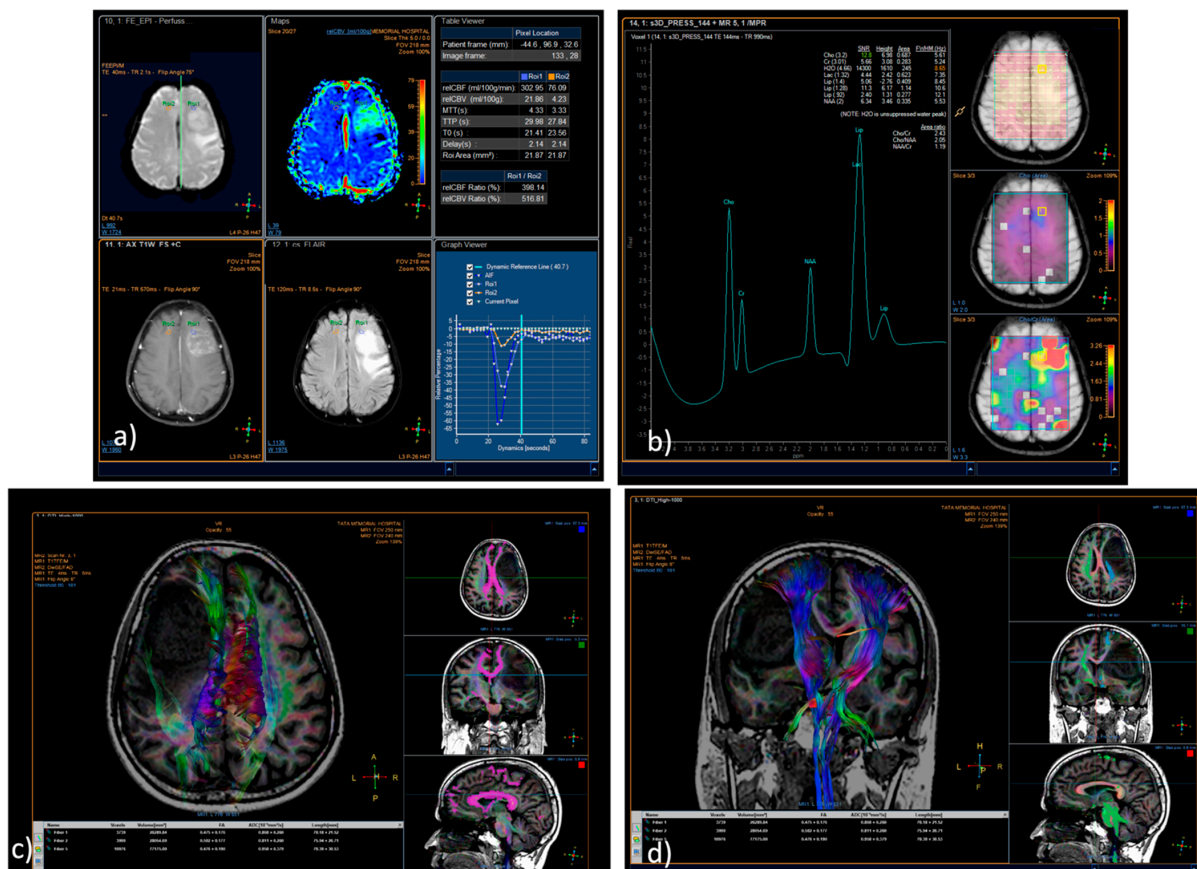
MRI brain—advanced sequences of the same patient as in Figure 1. (a) T2*/DSC-PWI shows elevated rCBV ~7 times in the tumor as compared with NAWM. (b) MRS shows an elevated Choline and decreased NAA, with Cho: NAA = 2.05 and Cho: Cr = 2.43. (c,d) DTI shows the proximity of the tumor to the speech association areas and corticospinal tract.
